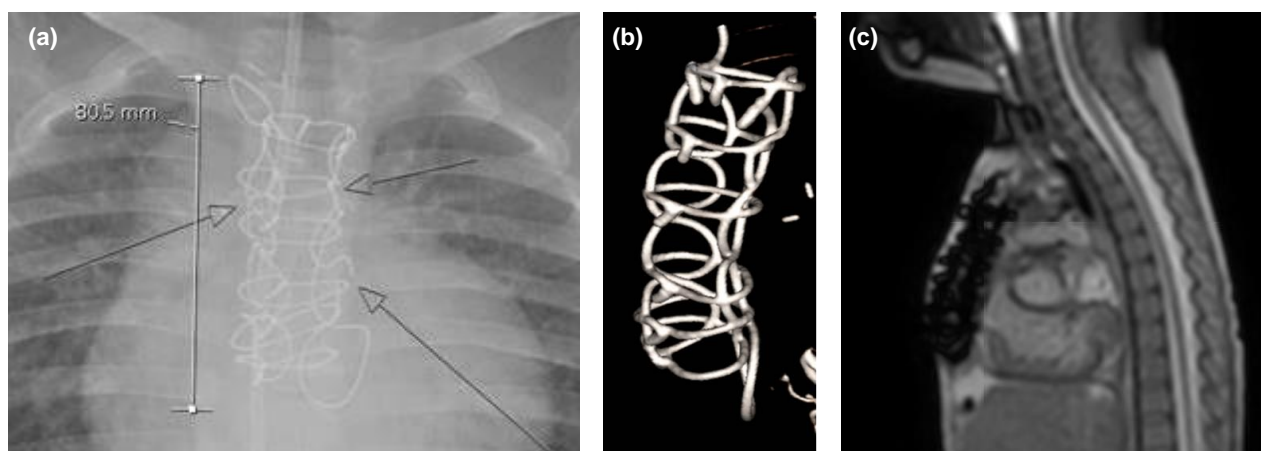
(a) Chest x-ray showing sternotomy closure system, (b) thresholded, volume-rendered CT image of the sternal closure system and (c) sagittal localiser MRI scan showing susceptibility artefact of the closure system.
